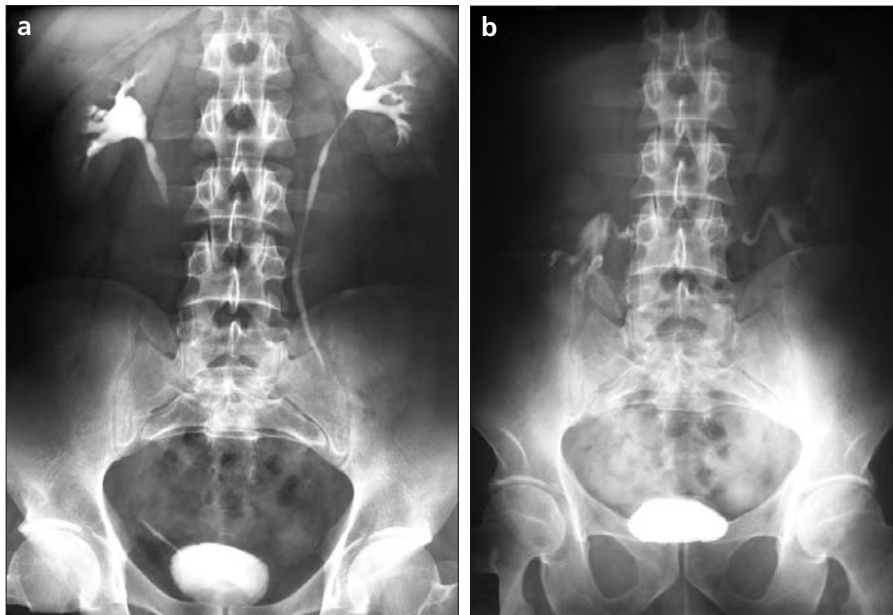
a, b. Nephroptosis. Supine (a) and upright (b) kidney-ureter-bladder radiographs show bilateral asymptomatic nephroptosis. The right and left kidneys have moved downward by 9 and 10 cm, respectively, in the upright positioning. Bilateral renal pelvises seem less visible due to the reduction of contrast material, and both ureters are invisible due to emptying (b).
